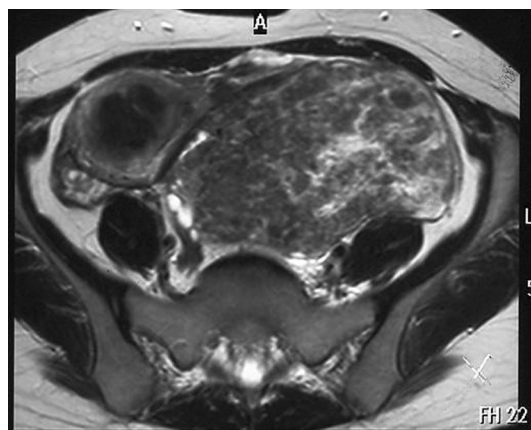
Axial T2 weighted MR image showing 2 separate fibroids.
